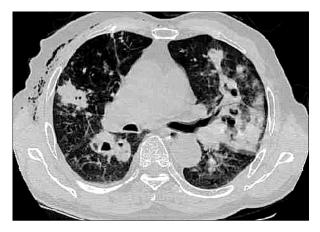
Chest CT scan showed multiple patch consolidations, nodules with cavity formations, and severe wall thickening of subsegmental bronchi in both lung fields.
